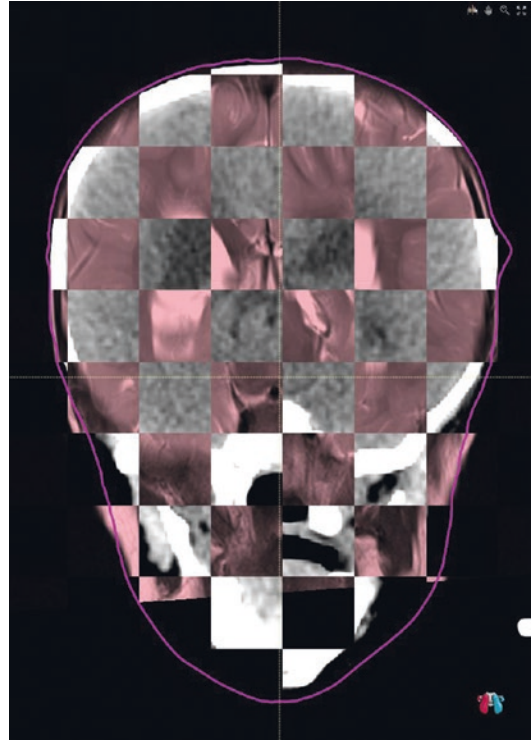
Display of image fusion for treatment planning in a child with a brain tumor (“checker”). *Legend:* White boxes; CT scans, pink boxes; MRI, T2 scans. Image from the radiotherapy planning system RayStation® (Version 7, RaySearch Laboratories, Stockholm, Sweden)
